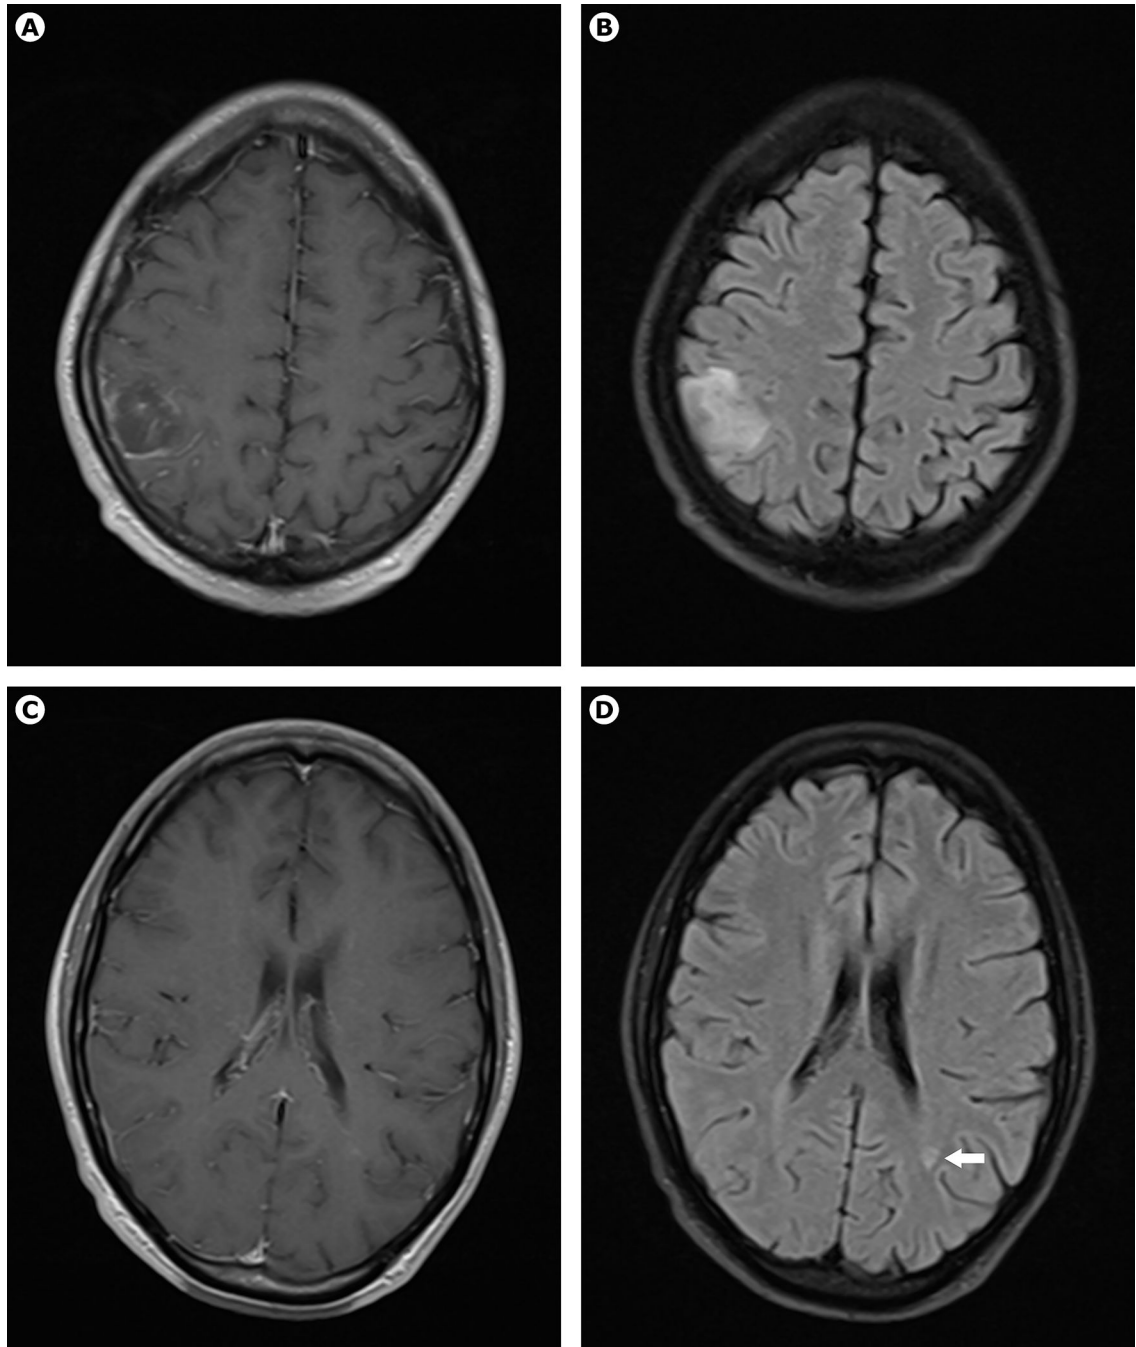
MRI brain obtained on admission
